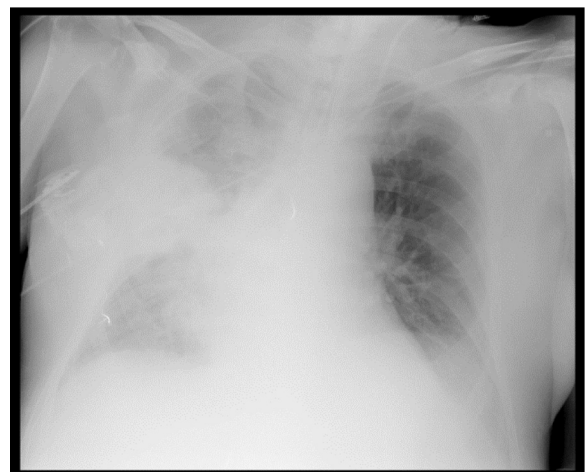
Chest x-ray on admission to our hospital.
